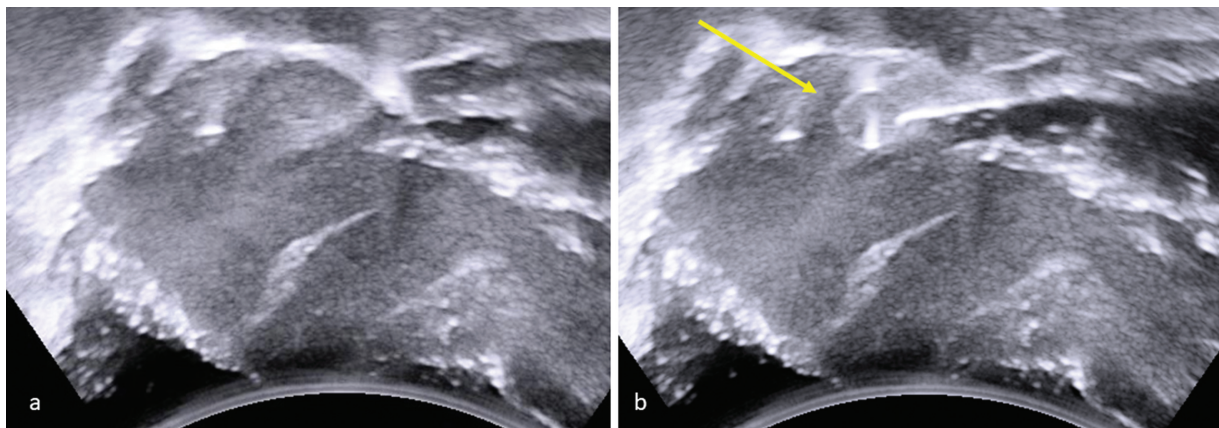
Ultrasound examination of hippocampus without (a) and with (b) transector (arrow) placed in the hippocampus.
